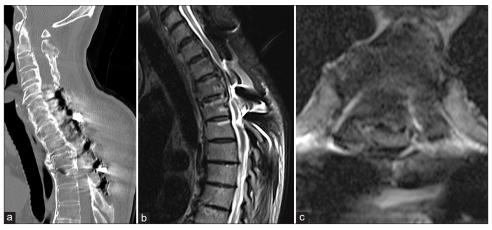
Postoperative CT and MRI images after revision surgery. (a) After revision surgery, T1-4 kyphosis angle was 23.3°. (b and c) Indirect decompression at the T2-3 level was obtained by dekyphosis. CT: Computed tomography, MRI: Magnetic resonance imaging.
